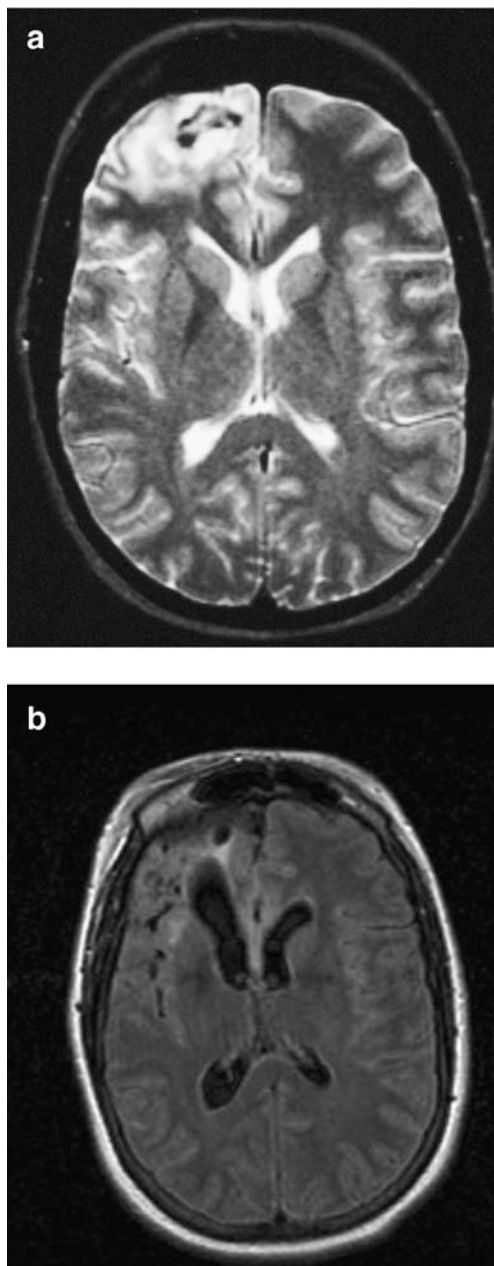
a Brain magnetic resonance imaging (MRI) (1998) revealing a 2.5 cm×4 cm right frontal lobe mass. b Brain MRI (2005) showing right frontal lobe encephalomalacia and diffuse meningeal T2 prolongation
